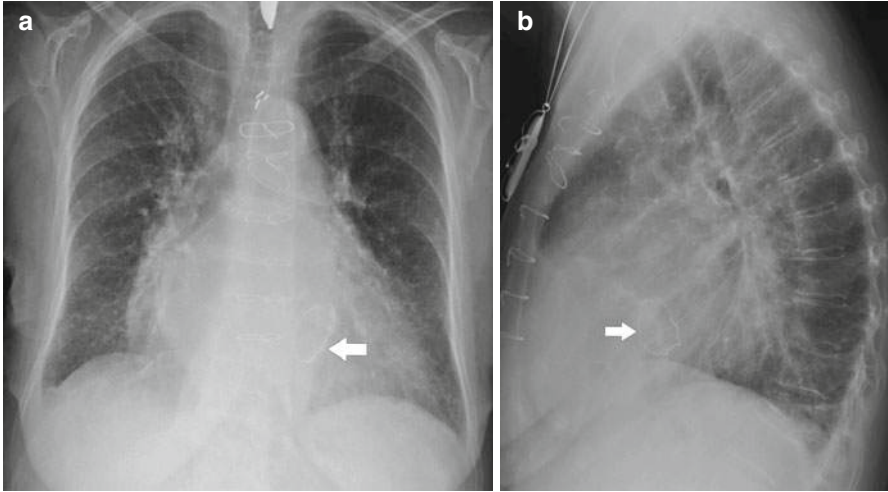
Cardiomegaly. Chest X-ray posteroanterior (a) and lateral (b) views reveal an enlarged heart and a prosthetic mitral valve (*arrow*)
